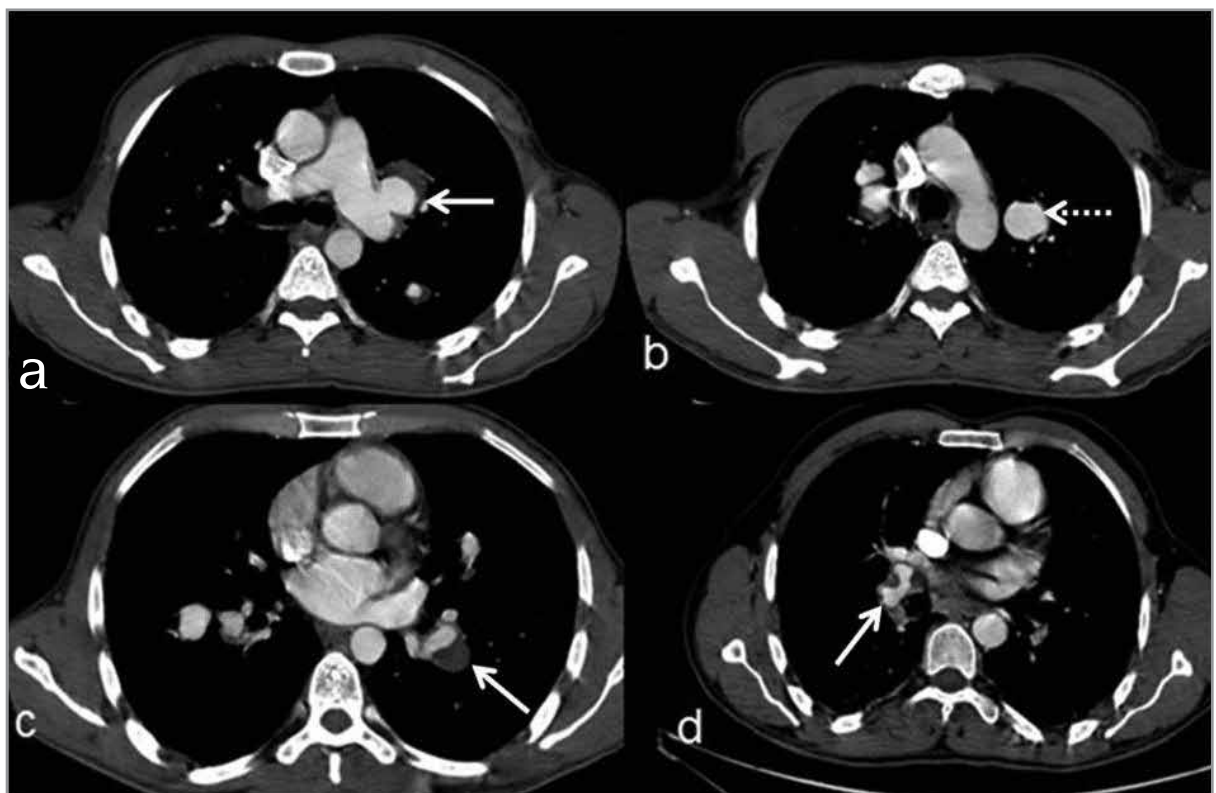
Bilateral giant saccular pulmonary arter aneurisms of a patient BD on pulmonary CTA. (a, b, and c from the same patient and d from an other patient). Some of aneurisms are partially thrombosed (arrow) and contain air (dashed arrow).
